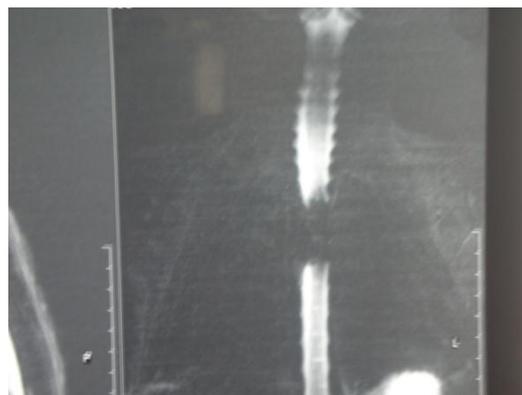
An MRI of spinal cord had evidence of mass at posterolateral
